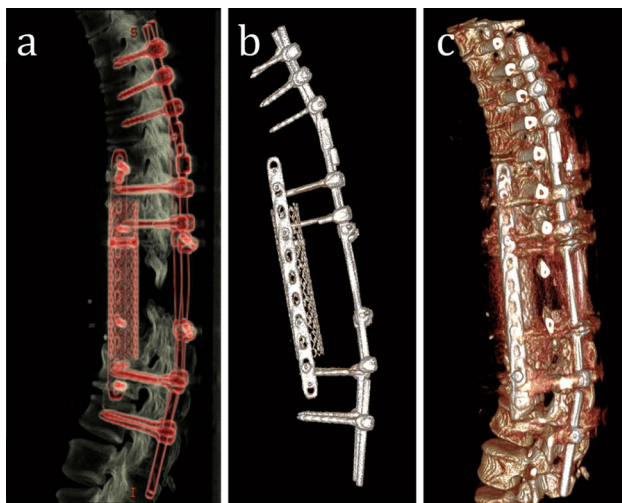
F/u 02/2015 3D CT scan of the spine. A situation after anterior–posterior stabilization during the 2015 control. The patient has no complains. a Lateral view on the 3D spin with implants in slight red; b only the implants are reformatted, and c implants are well integrated. No hint for implant failure. No fracture
